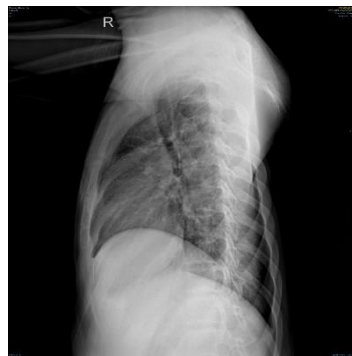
X-ray Thorax Lateral
